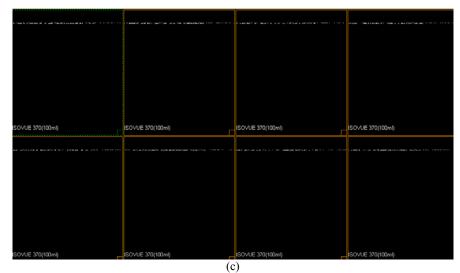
Example of the results of reformatted CT Coronal Chest volume. (a) Eight consecutive images of the original CT volume. (b) The same images as in (a) with a partial digital signature embedded. (c) The subtracted images between (b) and (a) showing where the digital signature is embedded.
